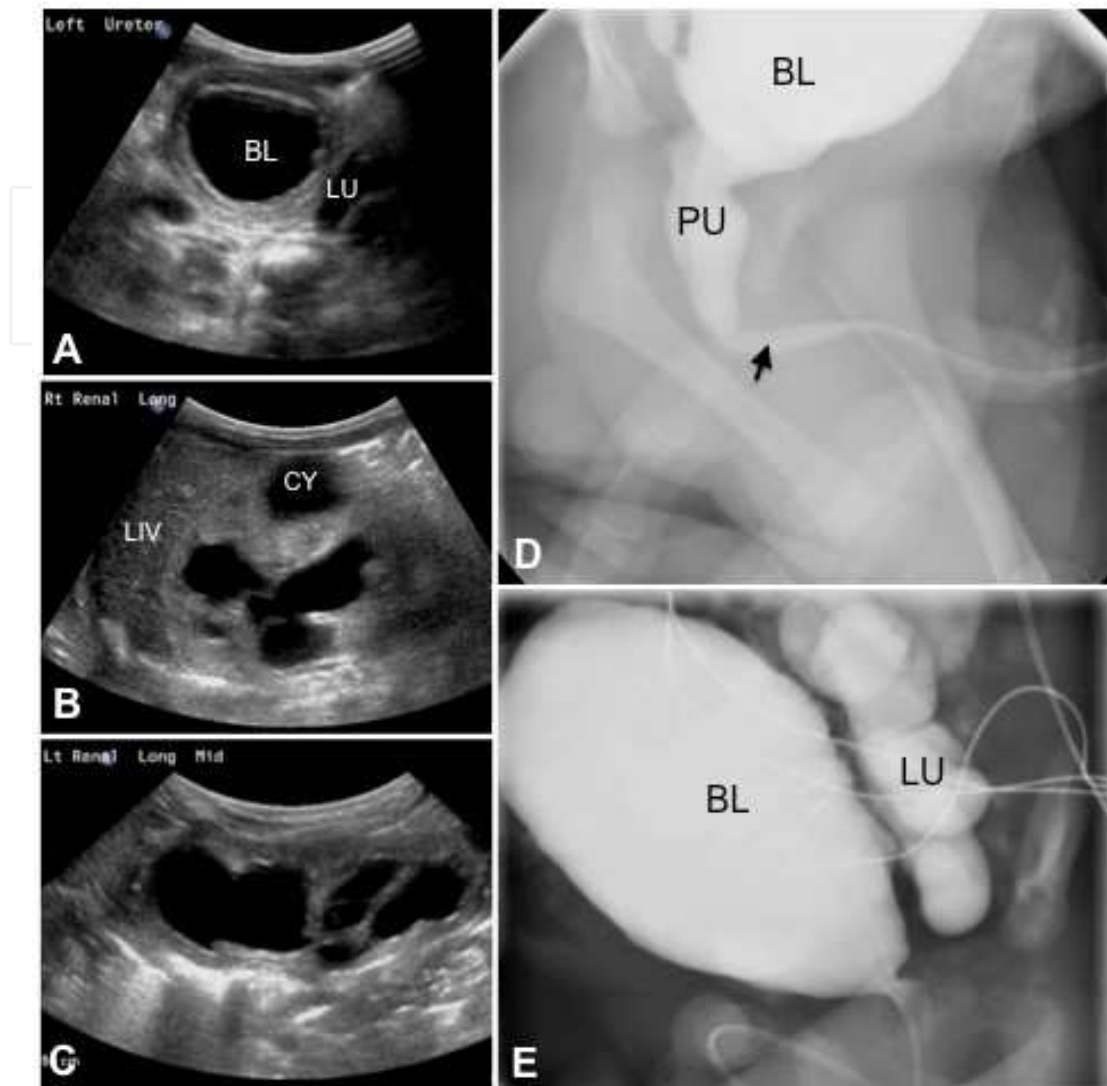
Radiological findings associated with PUV in a 2 day old male. A - C. Ultrasound of urinary bladder (A), right (B) and left (C) kidneys. The bladder (BL) is rounded with a thickened and trabeculated wall. This patient had severe hydroureter bilaterally, although only the left ureter (LU) is clearly observed in image A. Moderate to severe hydronephrosis is present bilaterally, with thinning of the cortex, increased echogenicity relative to the liver (LIV), and poor corticomedullary differentiation. One fluid-filled area (CY) in the right kidney did not clearly communicate with the collecting system, and likely represents a large cyst. D and E. VCUG. The lobulated and undulating contours of the urinary bladder (BL) reflect thickening and trabeculation of the bladder wall. The posterior urethra (PU) is dilated. Rather than the classic abrupt transition to a normal caliber anterior urethra, this patient has the “wind-sock” appearance generated by distal prolapse or distention of the valve membrane (arrow). VUR into a tortuous and dilated left ureter (LU) is obvious.
